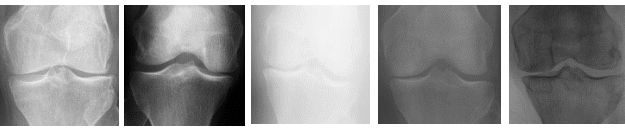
Similar Knee X-ray images corresponding to Grade 3 (Moderate Class).
